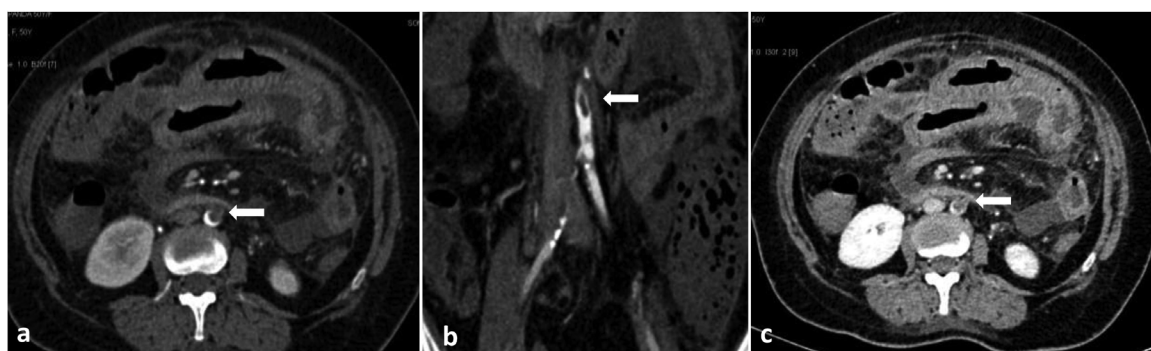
Contrast-enhanced computed tomography: Axial (a) and coronal (b) arterial phase images showing thrombus in descending aorta extending into the inferior mesenteric artery (white arrow). Axial venous (c) phase image showing the same.
